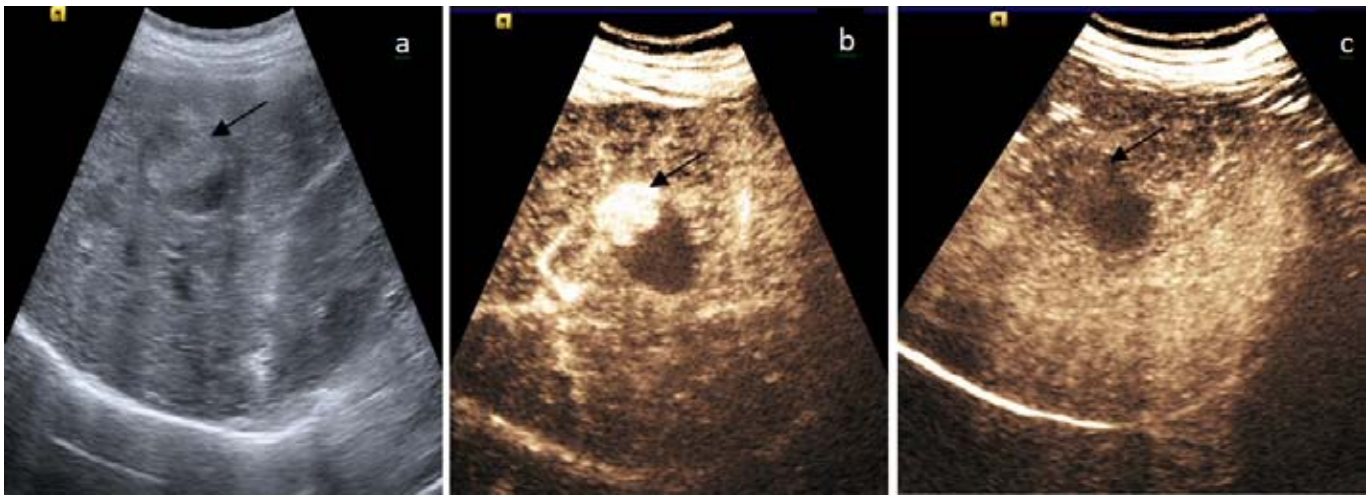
Grey scale ultrasound (a) following TACE showing a heterogeneous mass, hyperechoic area superiorly (arrow) with the remaining part as hypoechoic. CEUS was done which showed the same hyperechoic area showing intense enhancement (black arrow) on the arterial phase (b) [5 seconds] with washout (arrow) in the delayed phase (c) [190 seconds]. These findings were suggestive of residual disease at one month post TACE.
